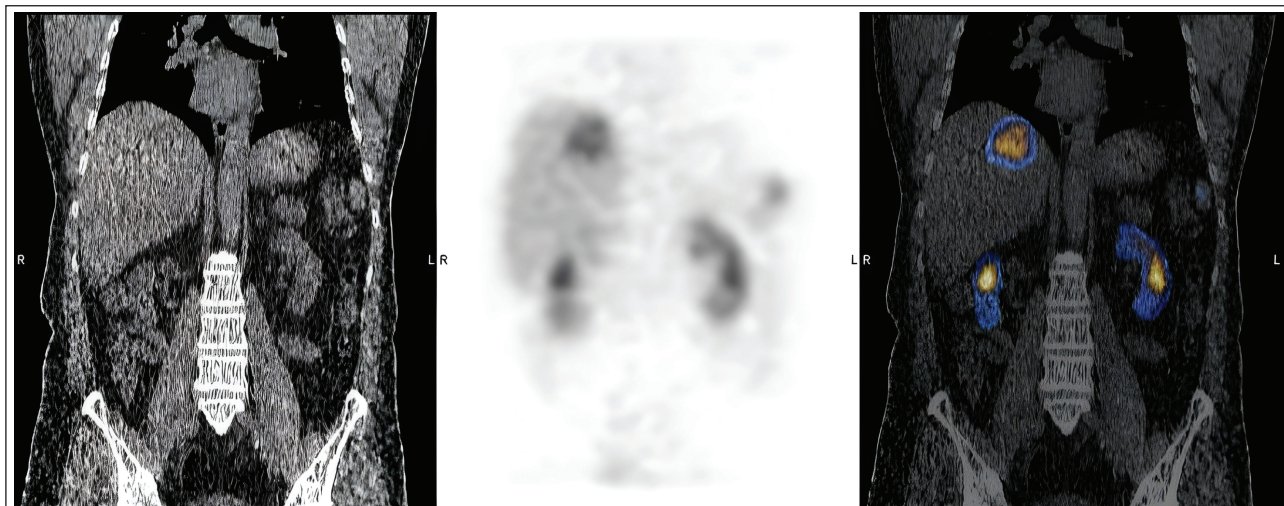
SPECT CT images of $[^{99m}\text{Tc}]\text{Tc-HYNIC-TATE}$ scan acquired 6 months after completion of four cycles of $[^{177}\text{Lu}]\text{Lu-DOTA-TATE}$ therapy in August 2024; showing an irregular shaped lesion with central area of necrosis in segment VII of liver.
